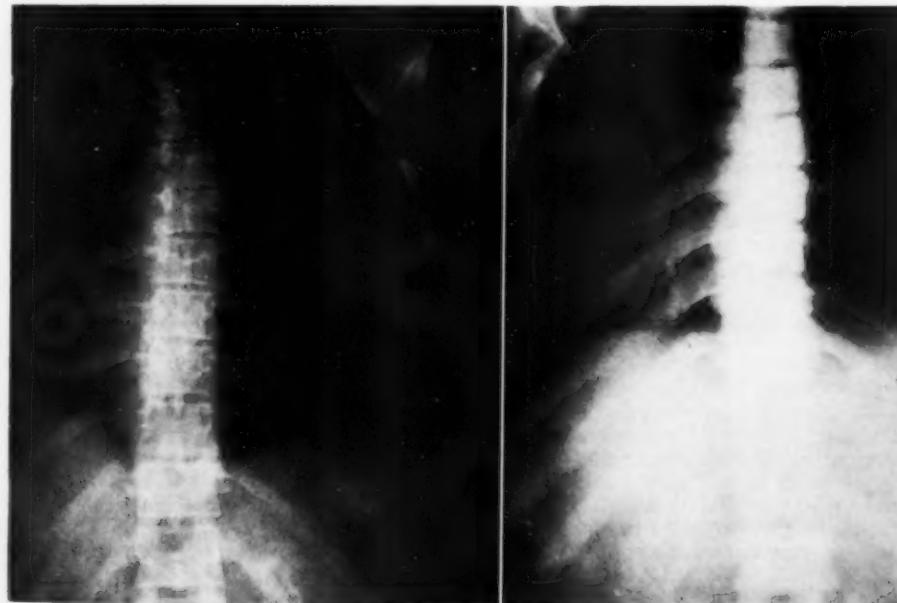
A normal roentgenogram of the adult thoracic cage is seen on the left, with the patient's on the right. Notice the thickened coarse trabeculae; where they are too thick, the appearance is chalk-like.
